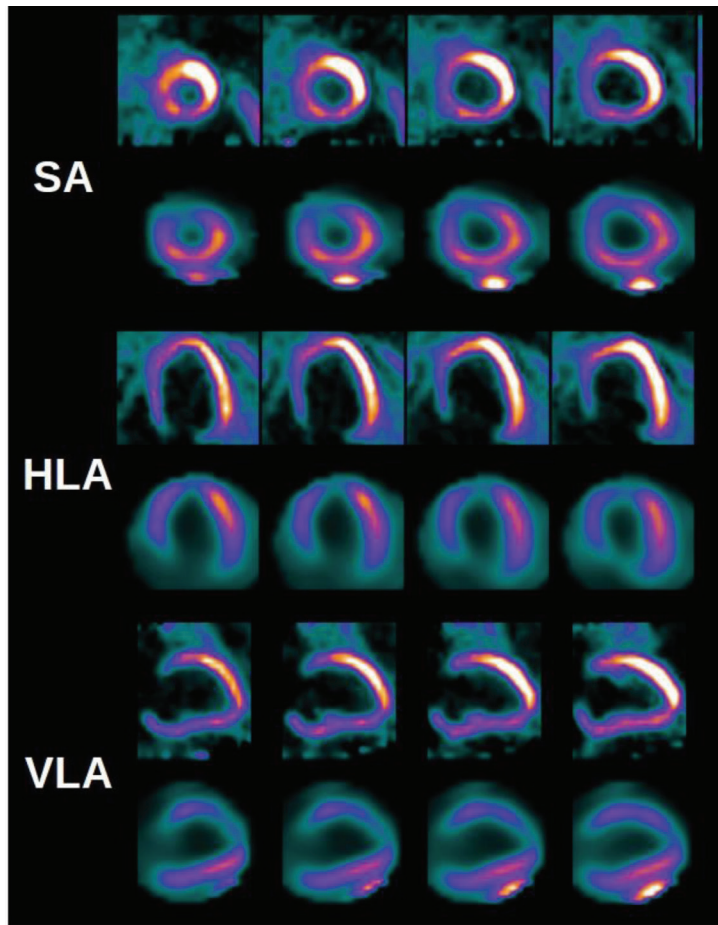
Comparison of myocardial glucose metabolism (¹⁸F-FDG PET) and myocardial perfusion (^{99m}Tc-tetrofosmin SPECT). Myocardial metabolism is shown in the top row and myocardial perfusion in the bottom row in each axis. Presence of myocardial metabolism in areas of reduced myocardial perfusion in the anterior wall signifies areas of hibernating myocardium. SA: short axis; HLA: horizontal long axis; VLA: vertical long axis.
